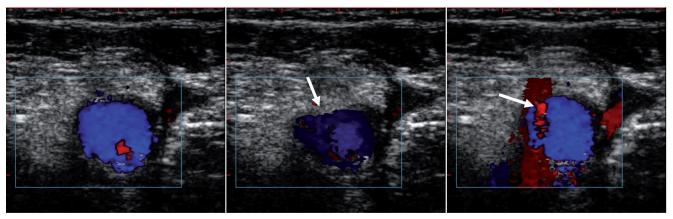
Ultrasound guided femoral artery puncture. Left: baseline femoral artery (Blue color Doppler). Middle: tenting of the artery by the approaching needle (arrow). Right: needle entry in the anterior vessel wall with typical red color doppler sign (arrow).
